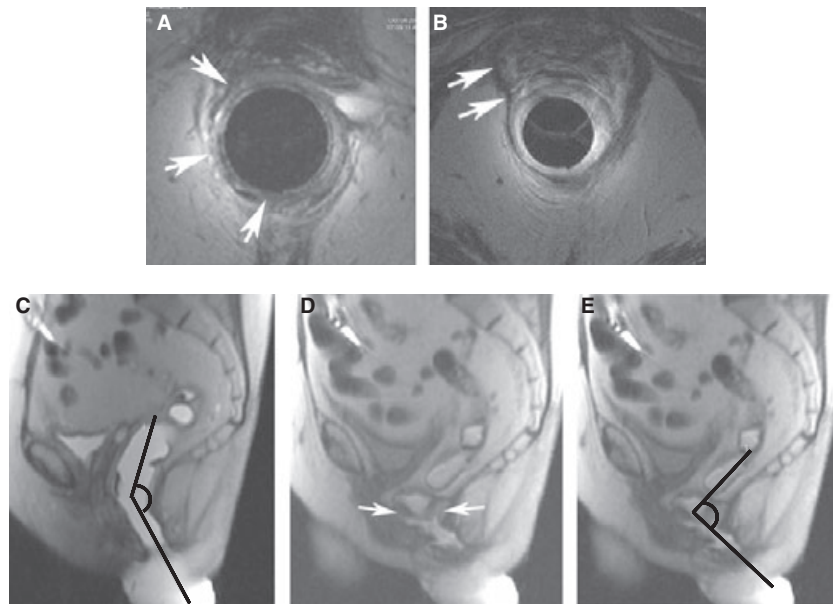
Static and dynamic pelvic floor imaging in defecatory disorders. In this, 69-year-old woman with symptoms of difficult defecation and fecal incontinence endoanal imaging revealed a right sided tear and atrophy of the internal and external sphincters respectively (A, arrows), and right puborectalis atrophy (B, arrows). Dynamic MR imaging shows a patulous anal canal at rest (C), rectal intussusception (D, arrows) and a reduction rather than widening of the anorectal angle during defecation (E).
